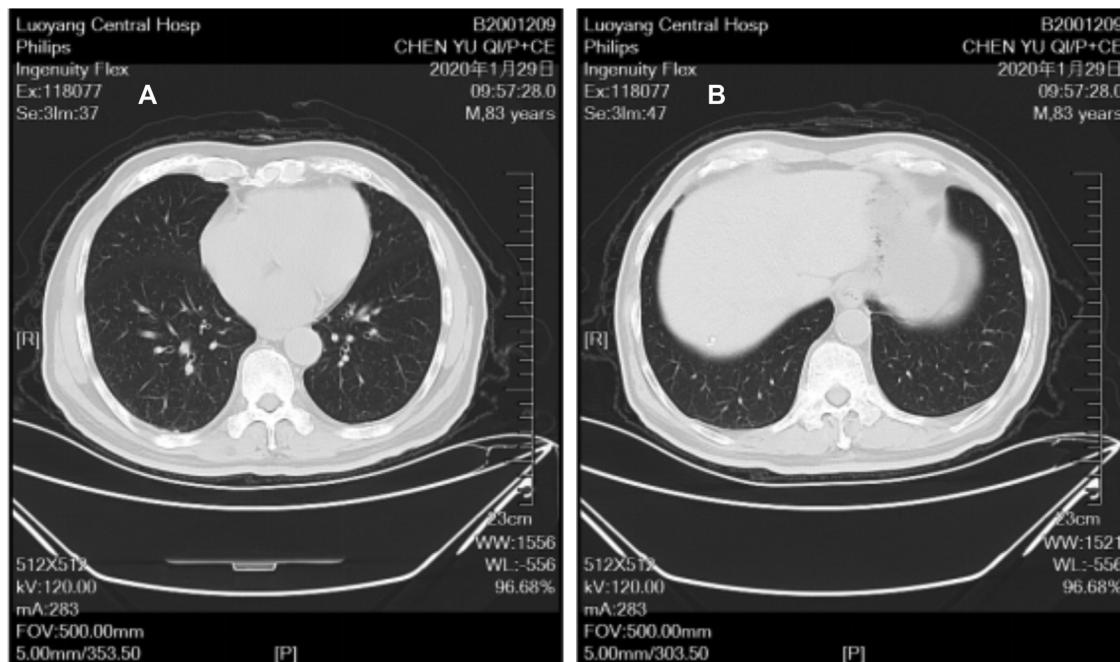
A and B. On January 29, computerized tomography (CT) scan images revealed no acute intrathoracic abnormalities.
